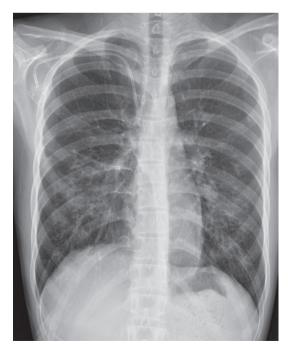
Chest X-ray obtained after treatment.
